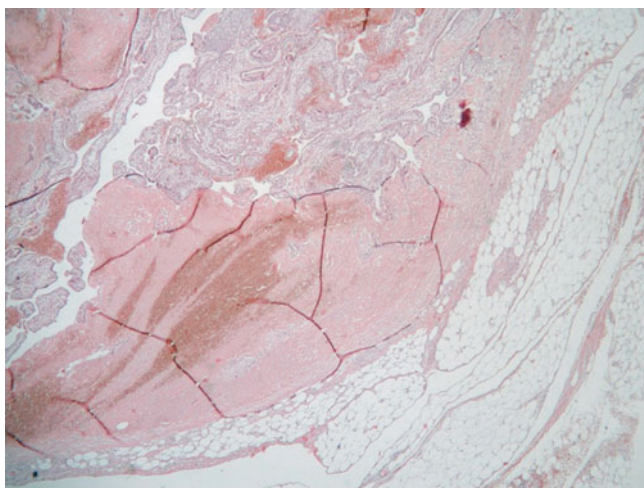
Thirty-year-old woman, previously treated with a bilateral salpingo-oophorectomy for subsequent tubal pregnancies, was submitted to a medically assisted insemination. At 10 weeks ultrasonography revealed a normal intrauterine pregnancy and a second pregnancy in the omentum. An omentectomy was performed. The large section of the omentum reveals the hemorrhagic pattern of the omental localization
